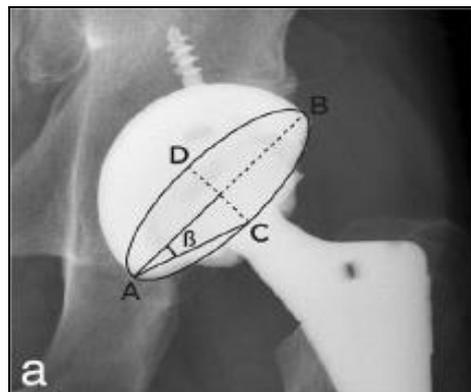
Measurement of the anteversion of the acetabular component on AP plain radiographs
